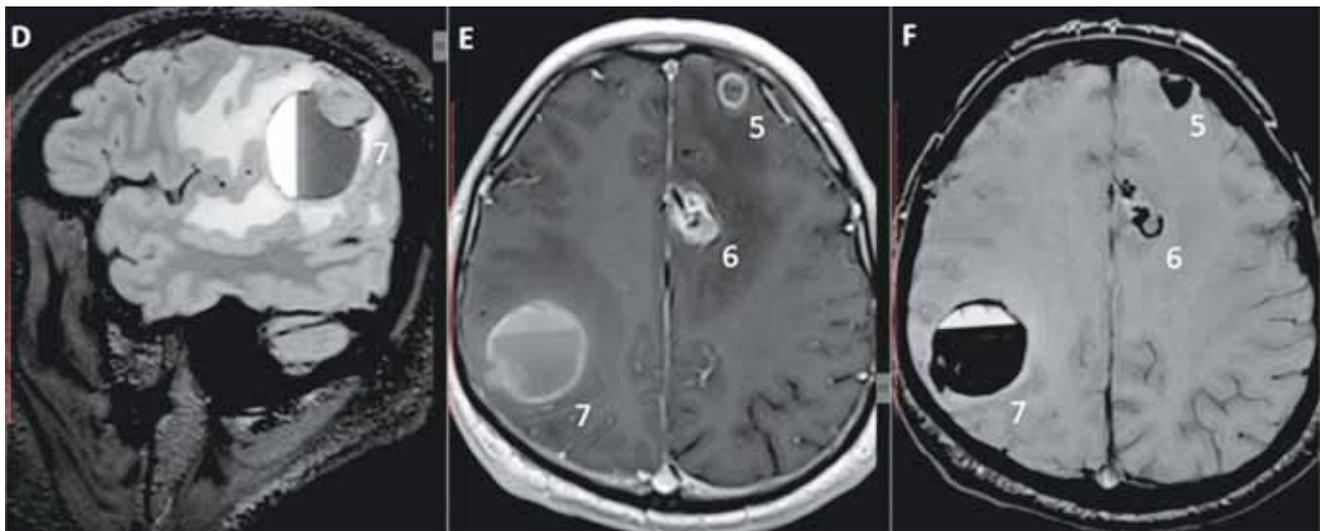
D – FLAIR, E – T1 + contrast, F – SWI. Lesion no. 7 displays an iso/hyperintense signal on FLAIR and T1/SWI signal loss in the right parietal lobe and an adjacent large hematoma with a fluid-blood level. Lesion no. 6 is in the medial region of the left frontal lobe and shows heterogeneous CE and SWI hypointensity. Lesion no. 5 is located in the anterior part of the frontal lobe and has both marked SWI signal loss and ring CE.
